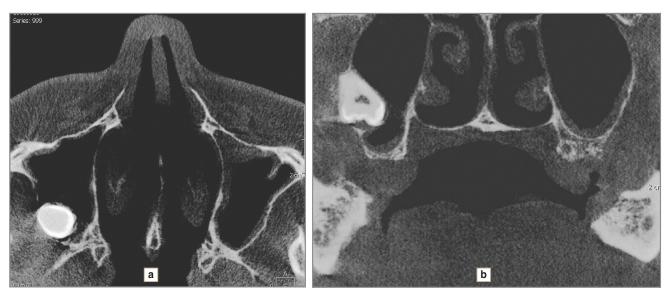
Computed tomography: *a* — axial and *b* — front views
